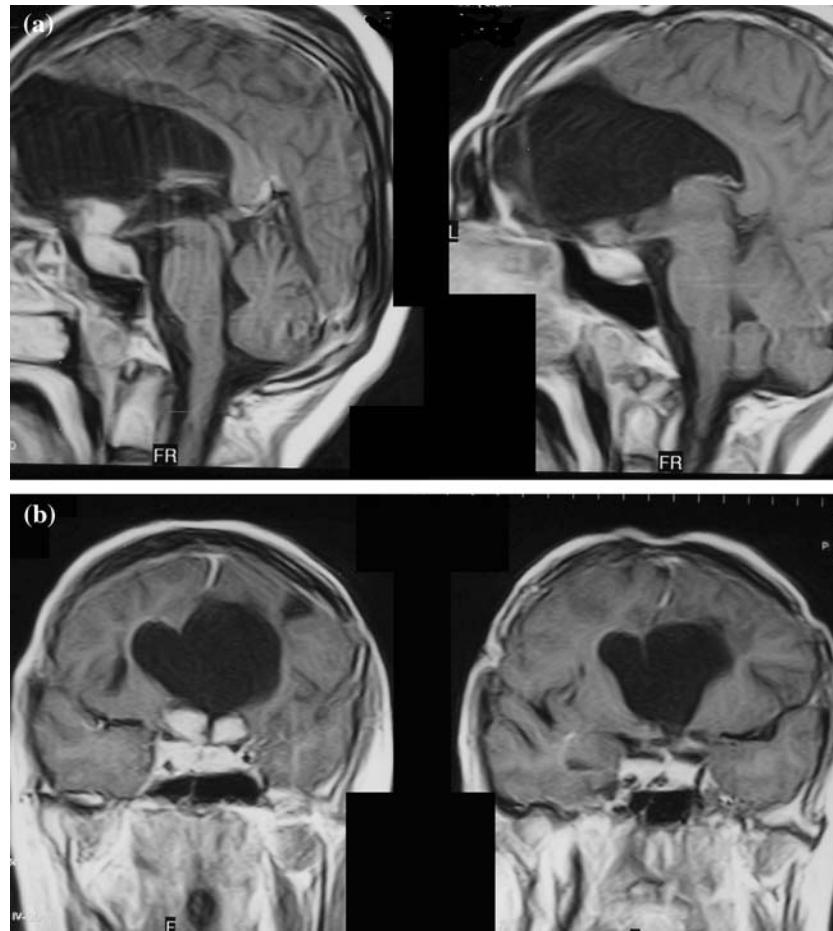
(a) Sagittal MRI showing an enhancing parasellar mass filling sellar and suprasellar cistern, (b) Coronal MRI showing a contrast enhancing parasellar mass filling sellar and suprasellar cistern and infiltrating both cavernous sinuses.
